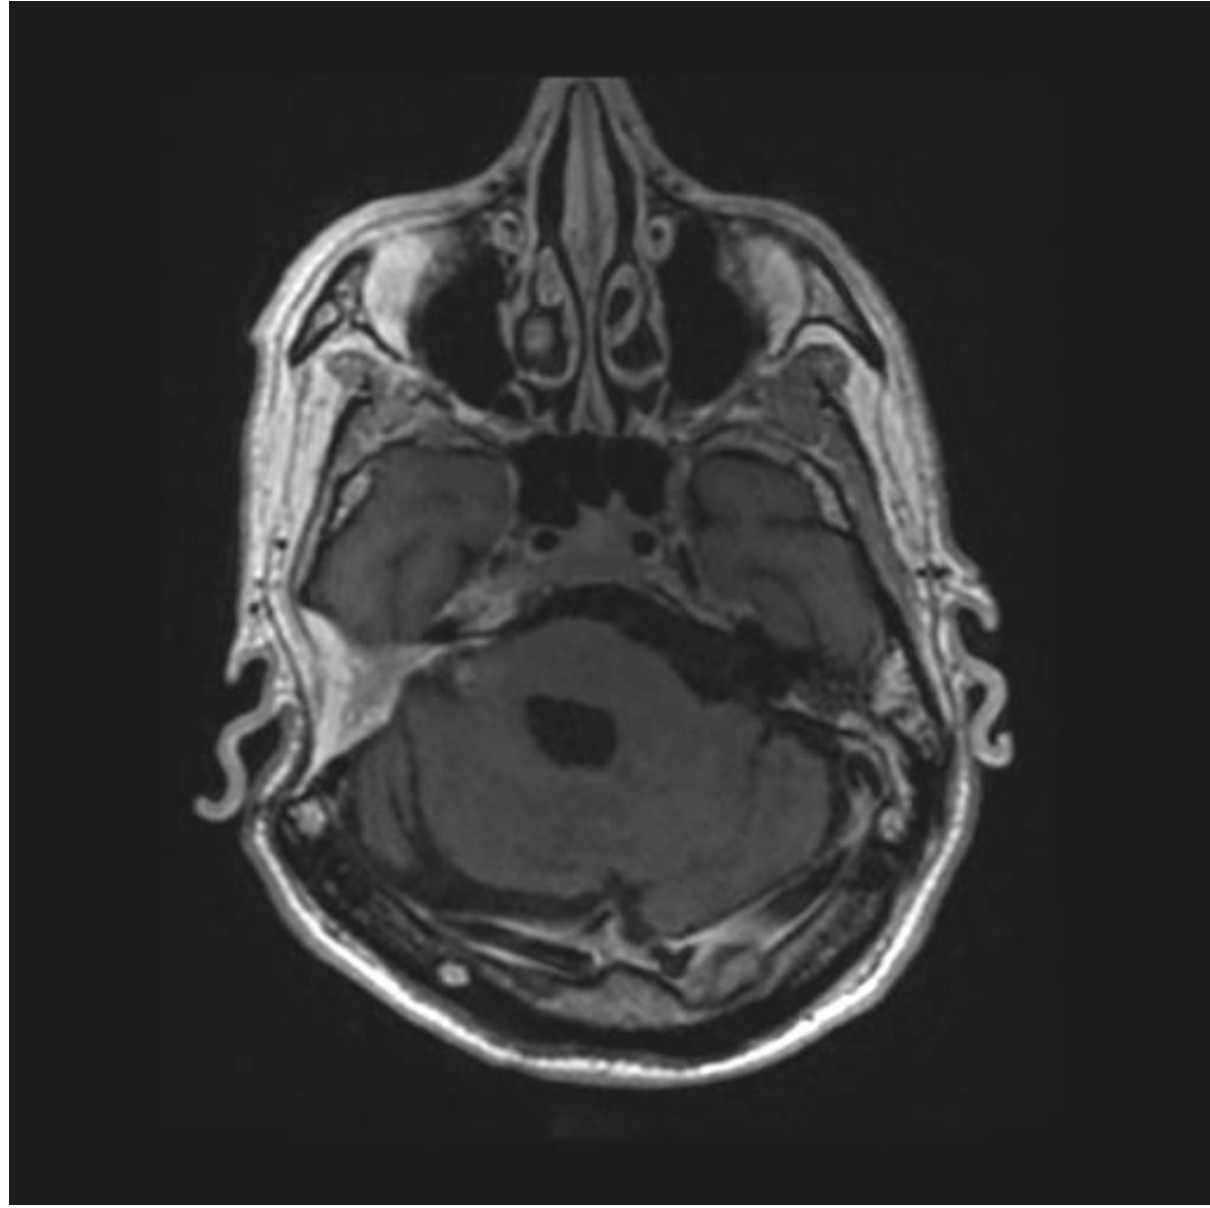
MRI demonstrating near complete resolution of mass and enhancement along brainstem.
